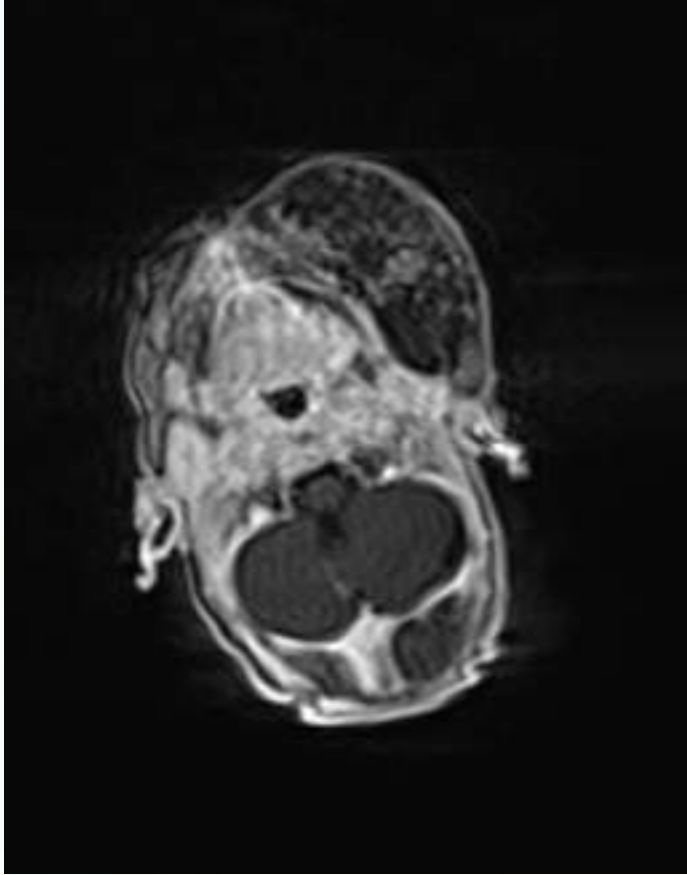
Postnatal MRI showing the facial lymphangioma.
